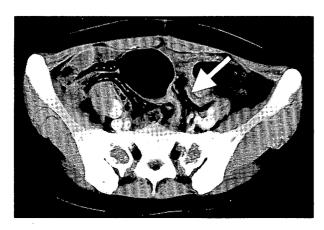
There is not critical point of torsion of the sigmoid colon observed on contrast enhanced CT. The axis of the mesenterium of the sigmoid colon is not twisted (arrows).
